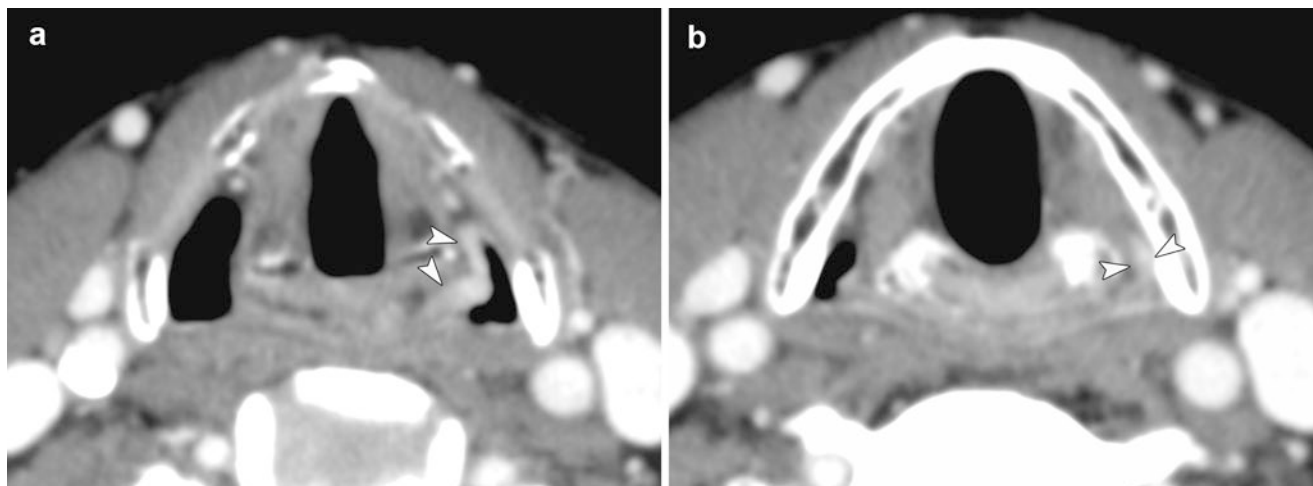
Early hypopharyngeal carcinoma treated by radiation therapy. (a) Contrast-enhanced CT exhibits an enhanced tumor of the left medial pyriform sinus to the post arytenoid area (arrowheads). (b) Axial
